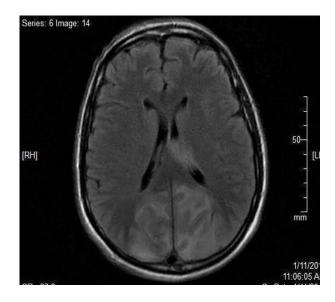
MRI with T1-weighted images showing edema and abnormal signal bilaterally in the occipital lobes, thalami, and inferior medial temporal lobes.
